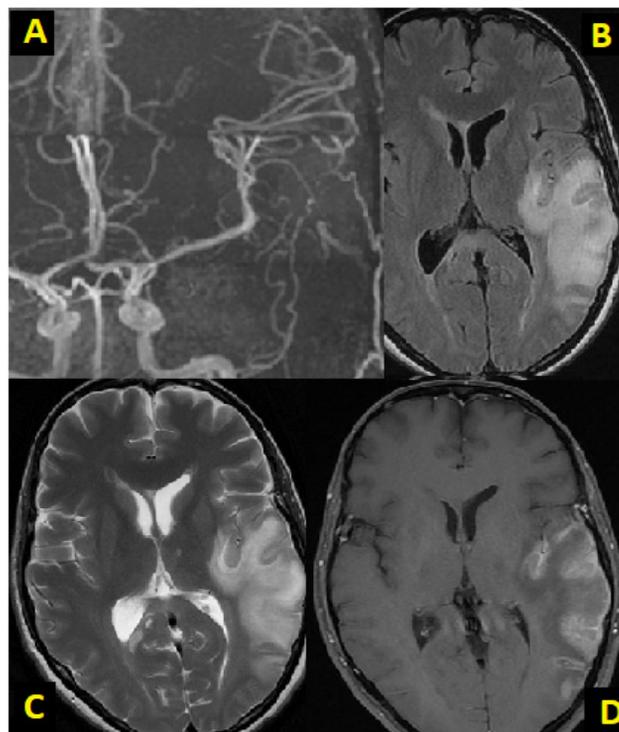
Follow up imaging. (A) MR angiogram showing complete recanalization of the left MCA. (B) FLAIR, (C) T2W and (D) T1W sequences showing residual infarct with most of the penumbra salvaged.
